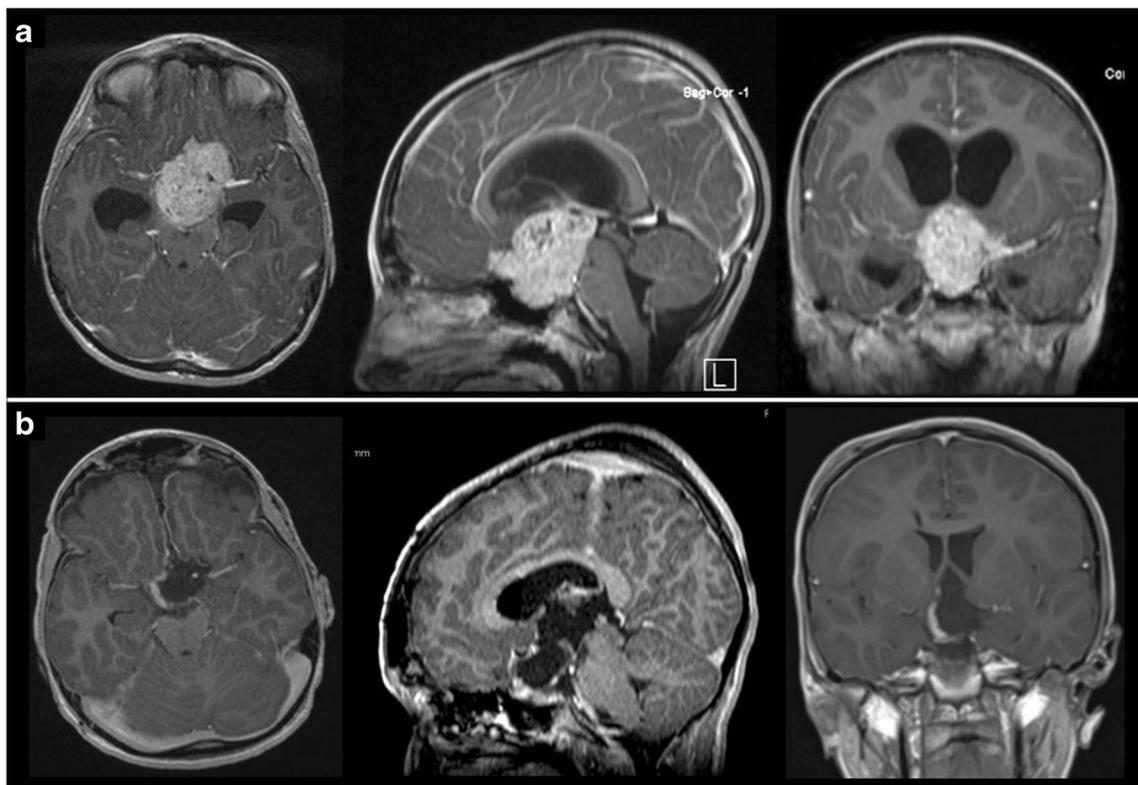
a Pre-operative axial, sagittal, and coronal T1-weighted post-contrast MR images showing a large third ventricular lesion. b Post-operative axial, sagittal, and coronal T1-weighted post-contrast MR images
